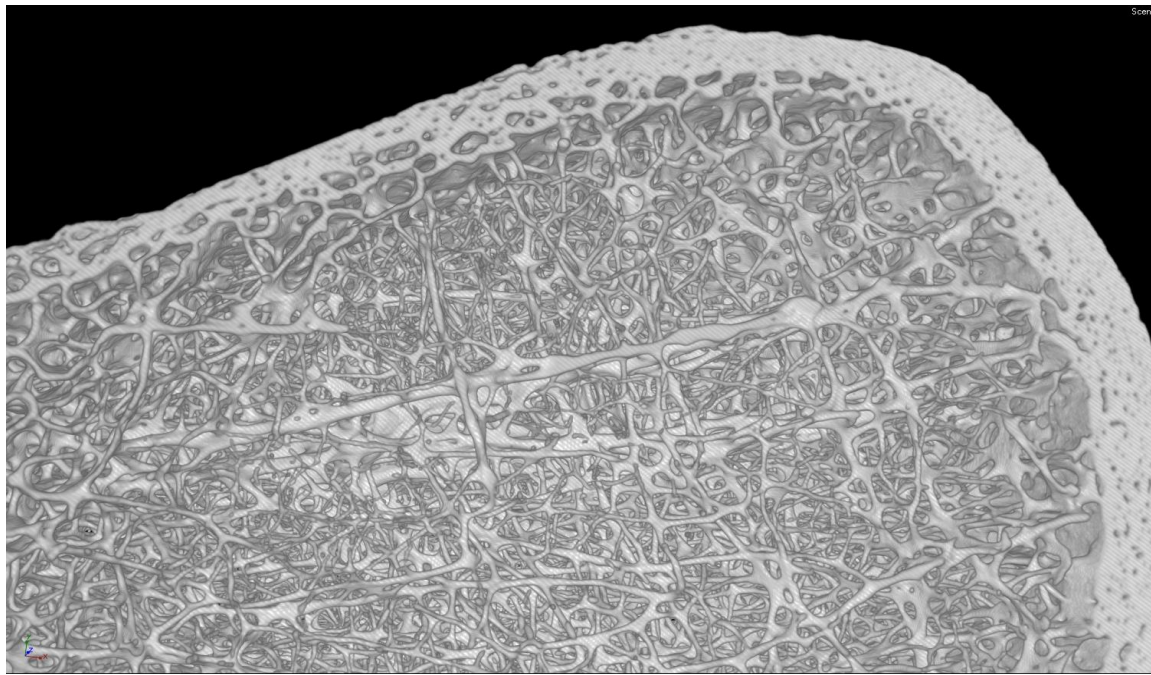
Close view of three-dimensional reconstruction of experimental bone block after being scanned with μ CT
